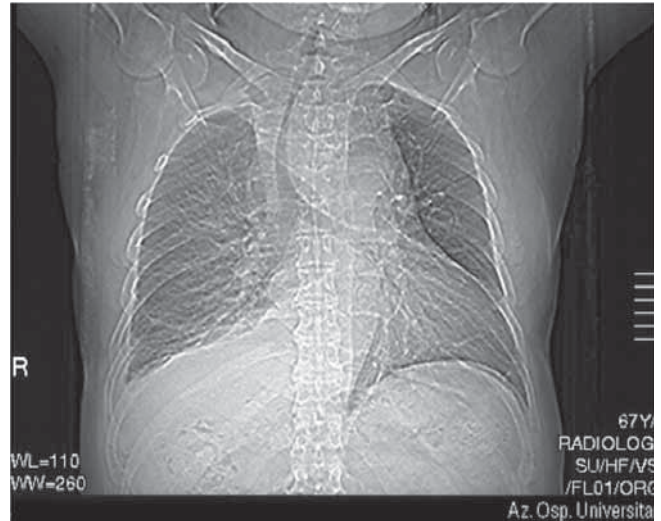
Coronal CT scan showing RG exerting significant tracheal compression and deviation.
